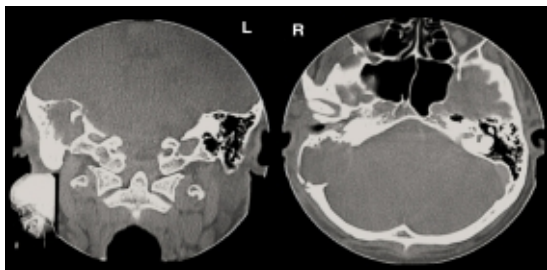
Coronal and axial CT images show fullness of right middle cavity with extension into the mastoid air cells (a) and posterior fossa (b).
